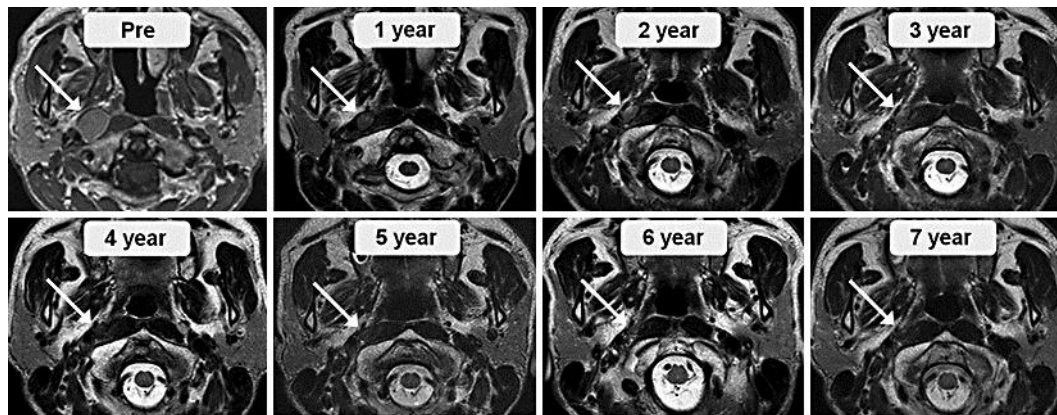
MRI with gadolinium-enhanced T1-weighted image before (Pre) and with T2-weighted images after SBRT. Arrows indicate the right RPLNm.
